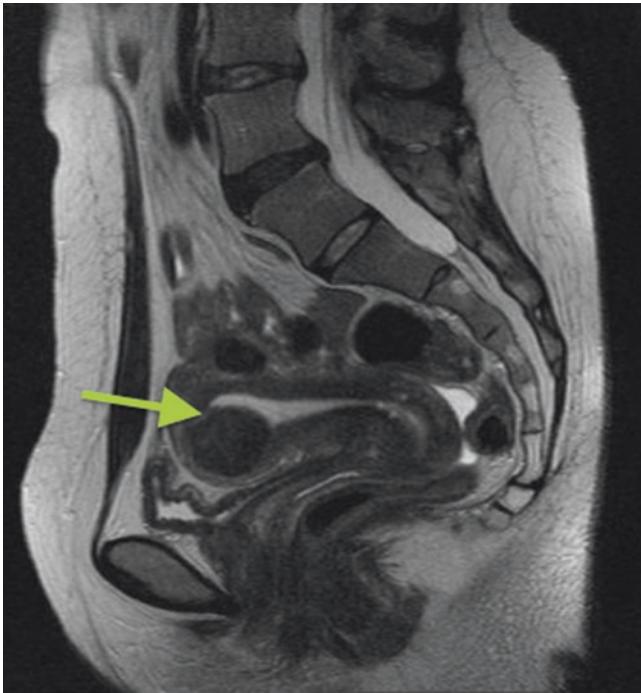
MRI of the pelvis, sagittal, T2 weighted, showing uterine nodule with hyposignal (*arrow*), presenting intramural and submucosal component
